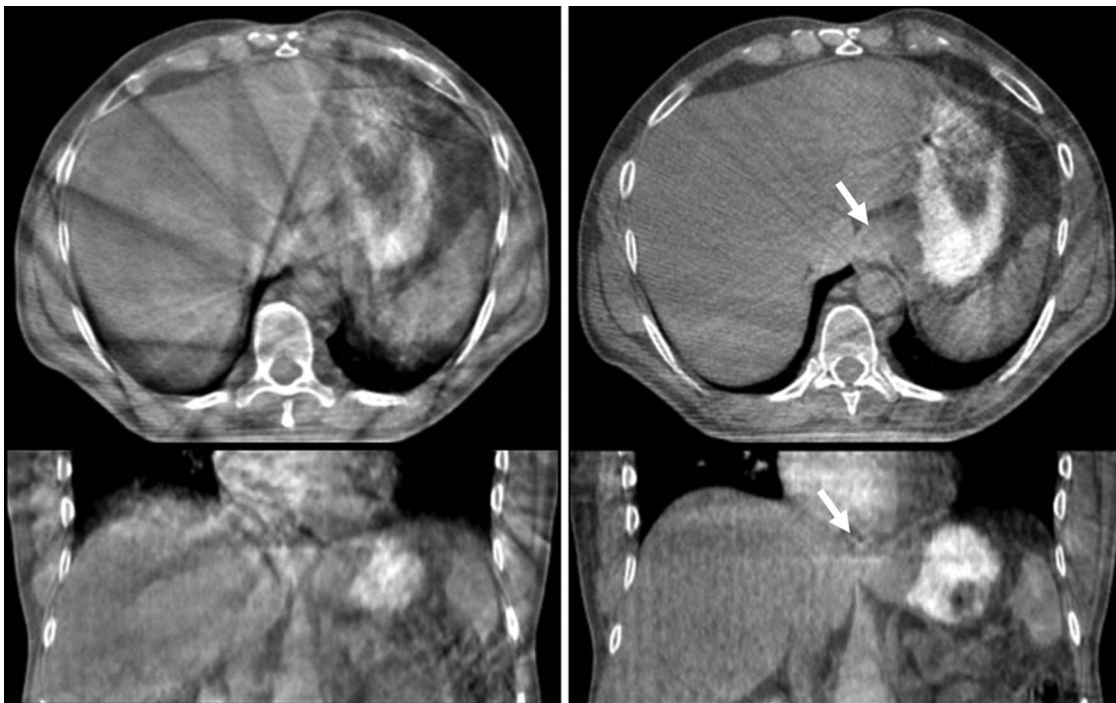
(Top and bottom) Transaxial and coronal CBCT images of free-breathing patient with tumor in GE Junction. Image planes intersect in the GEJ. Left column is standard CBCT, right is gated CBCT. Arrows indicate GEJ in the gated CBCT.
